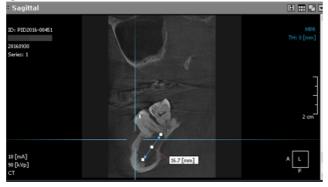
a CBCT scan, the visualization in the sagittal plan; a mandibular cyst with the mesio-distal dimension of 11.4 mm
